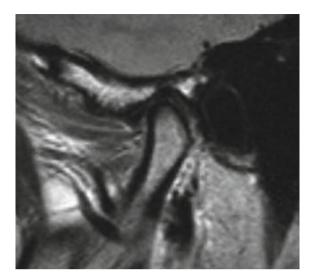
Magnetic resonance images show the healthy TMJ disc position. The posterior band of the disc is located above the apex of the condylar head (at the 12 o'clock position) with the mouth closed [24, 37]
